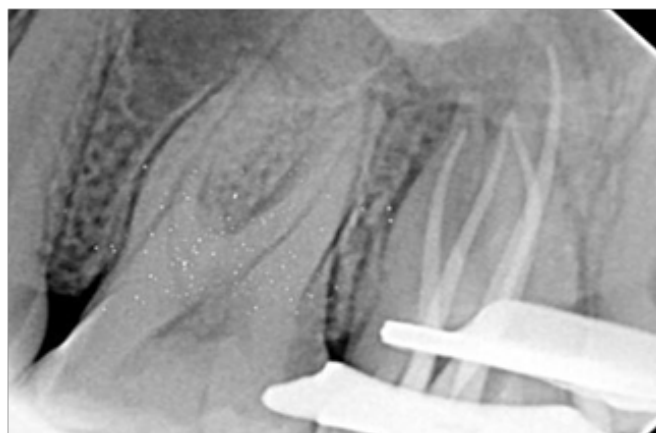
Radiograph with master cone
